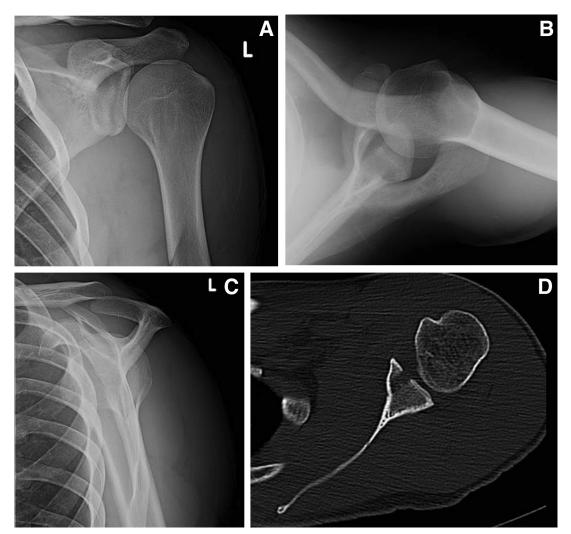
Preoperative (A) anteroposterior, (B) axillary, and (C) scapular-Y view radiographs, and (D) axial cut of computed tomography scan showing an intra-articular Ideberg glenoid fracture.
